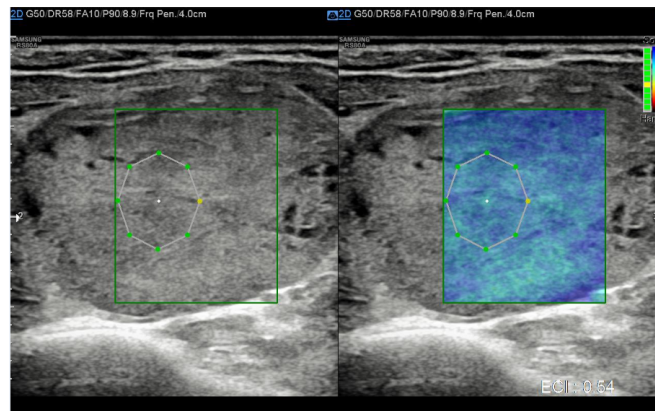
A 32 year old female patient, whose ultrasound had spongiform isoechoic nodule, well defined margins, ragos criteria 2, ECI 0.5, on FNAC, it is BETHESDA category II and diagnosis is benign follicular nodule
